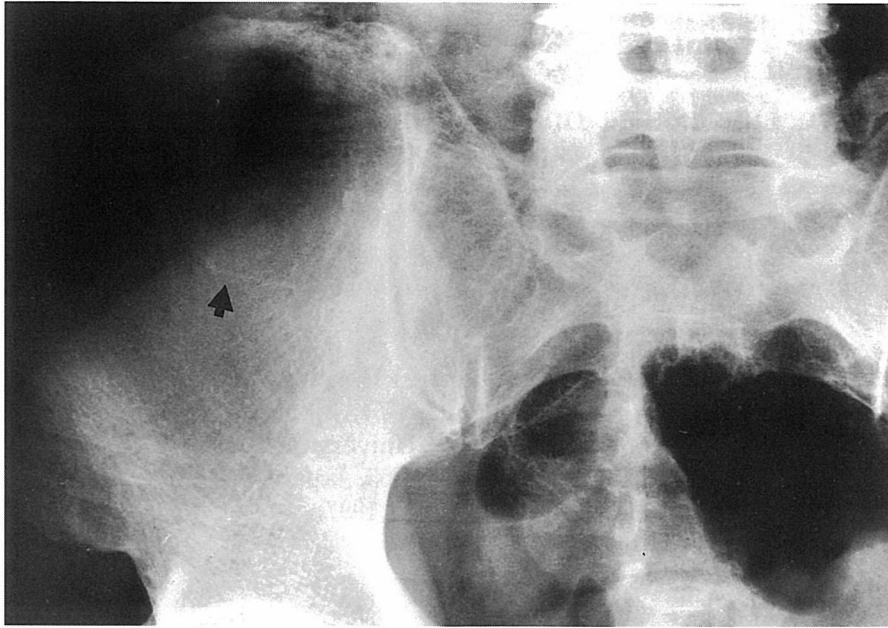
Abdominal plain radiograph reveals radiopaque linear shadow (arrow) on the right lower quadrant.
